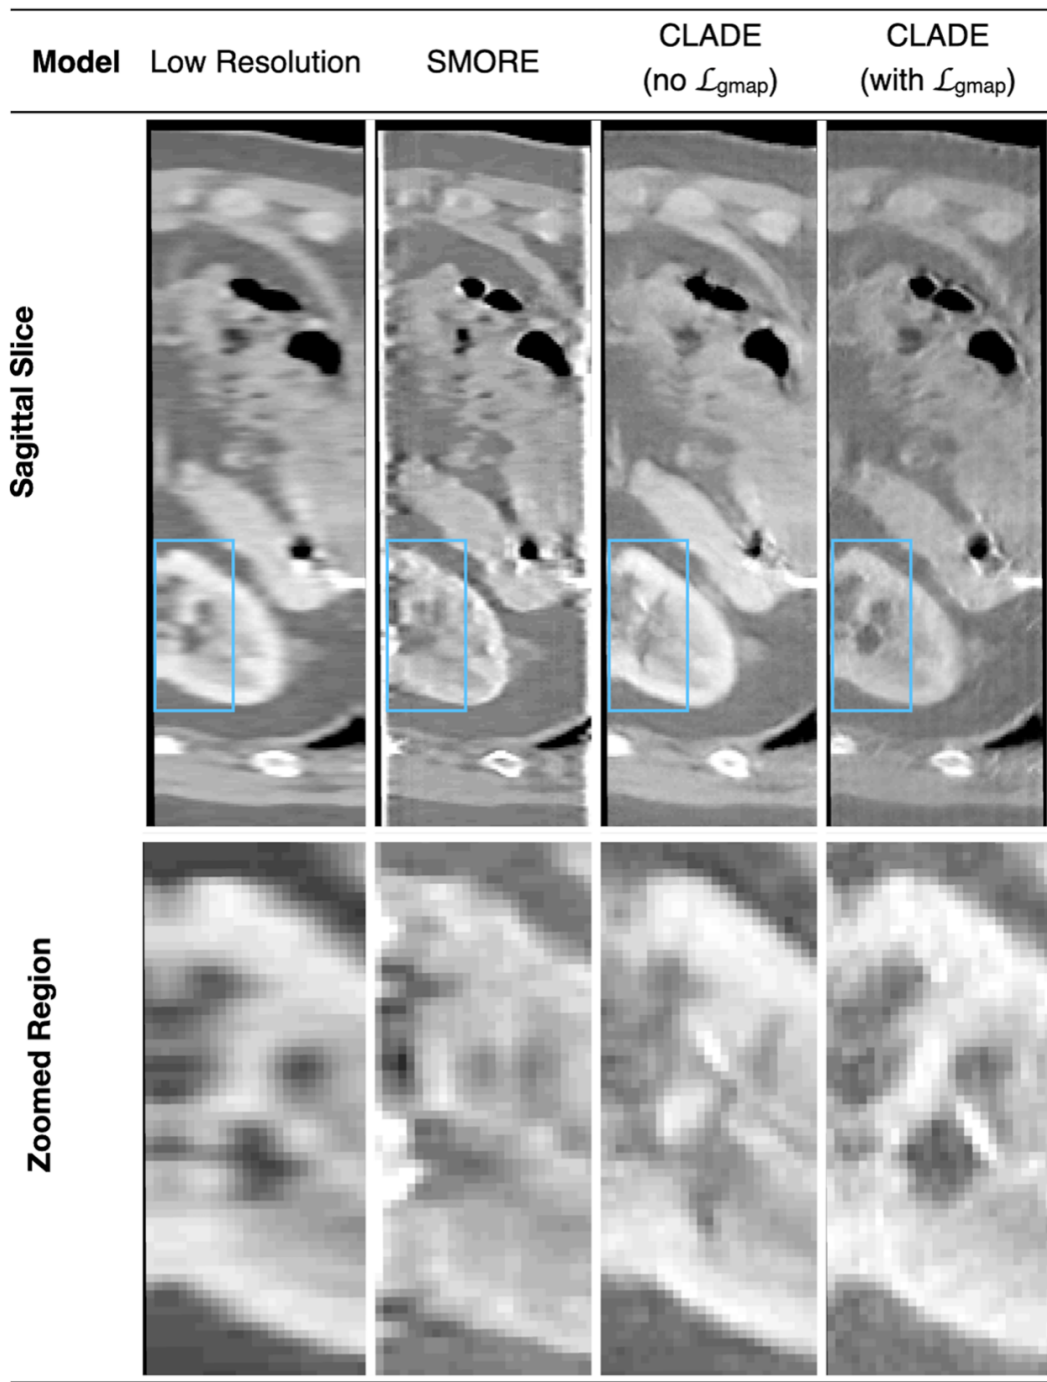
An example of sagittal image quality from SRR applied to a low-resolution CT data from one subject in the test dataset. Note that the SRR models are applied in the low-resolution sagittal plane for the CT data. Magnified regions within the blue box are displayed beneath each image.
